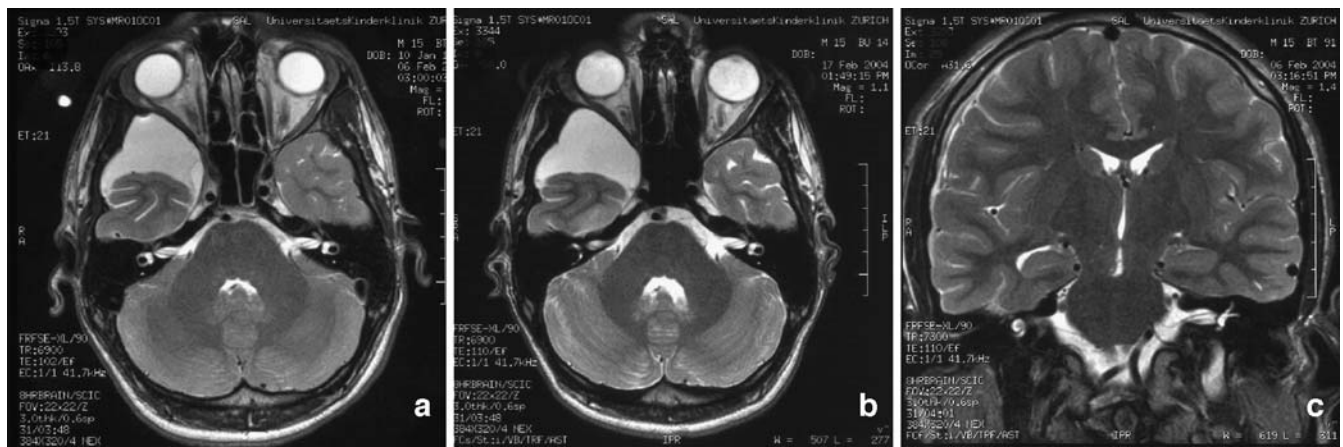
Serial axial (a, b) and coronal (c) T2-weighted fast spin-echo MRI. The early and follow-up axial images show an intact arachnoid cyst within the left middle cranial fossa in combination with a moderate temporal lobe hypoplasia (a, b) The pons is slightly
